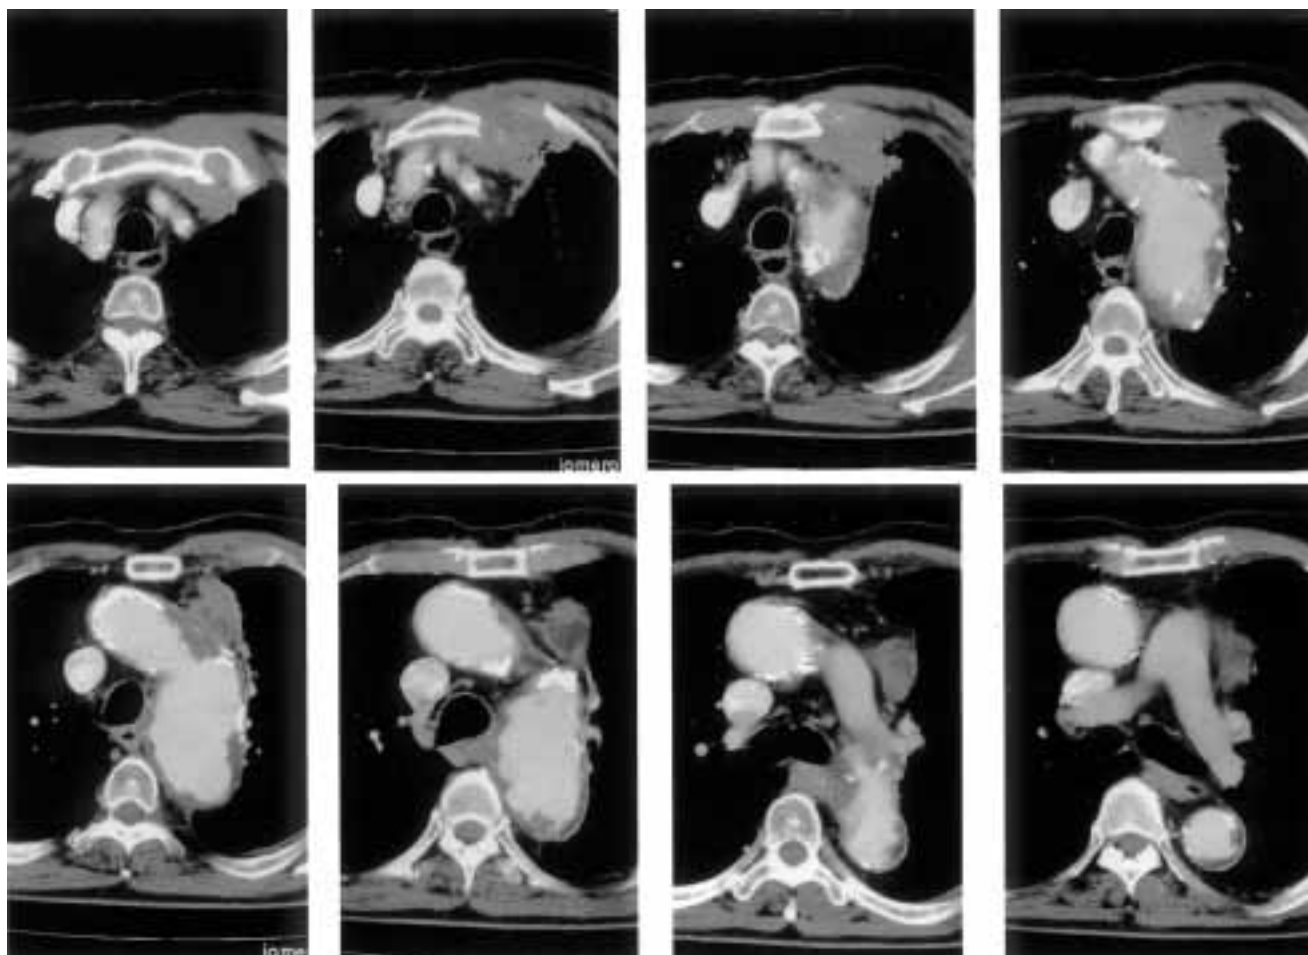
Chest computed tomography in a patient with a thymic carcinoma and a thoracic aortic aneurysm. Note invasion and destruction of the sternum.
